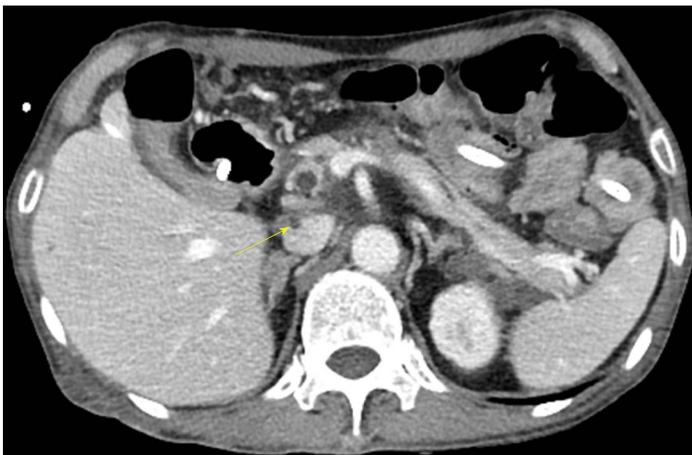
Computed tomography of the pancreas. Thrombosis in the inferior vena cava (yellow arrow) is seen.
